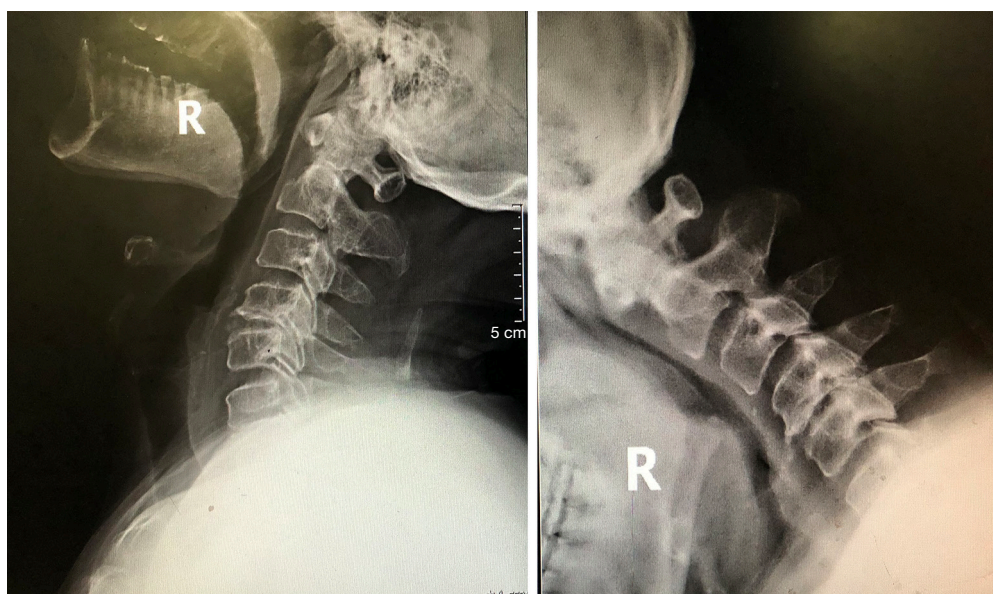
The hyperflexion-extension plain film examination of case 3 shows a loss of activity in the posterior atlanto-occipital interval.
